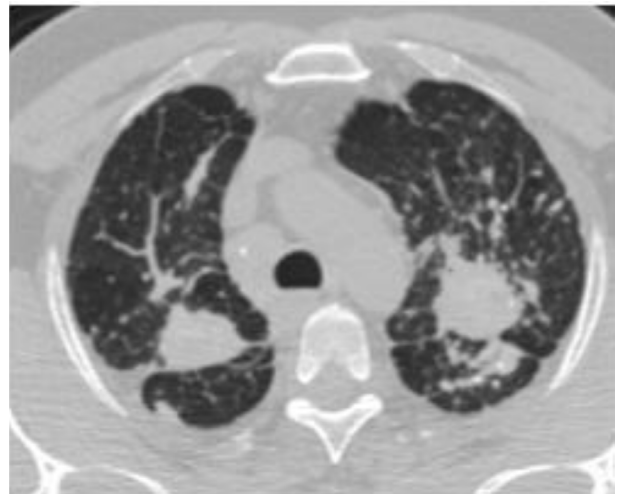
a) On the chest X-ray, large opacities at both upper lobes of the lung were hardly detected due to the rib superposition. b) With high-resolution computed tomography, 35-mm-wide large opacities are easily demonstrated, bilaterally in the upper zones.
